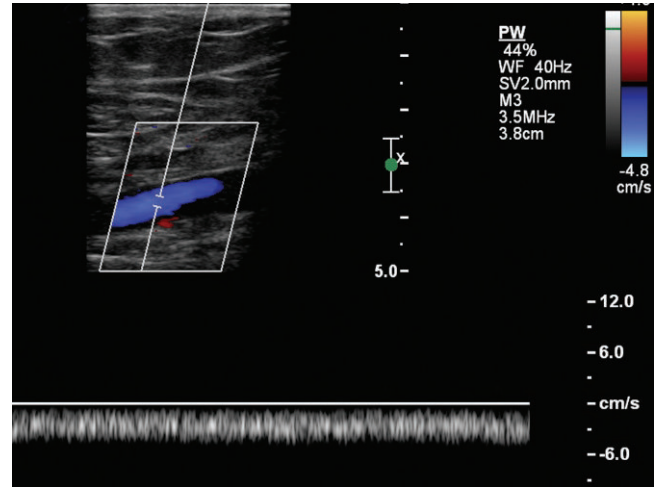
The contralateral common femoral vein is patent by color but there is an asymmetric continuous right spectral Doppler waveform. This indicates obstruction between the site of the sample and the heart. Since the other side is normal, the obstruction is in the common femoral vein above this, the iliac vein, or the left pelvis. Inferior vena caval involvement is ruled out when there is a unilateral blunt common femoral vein waveform.
